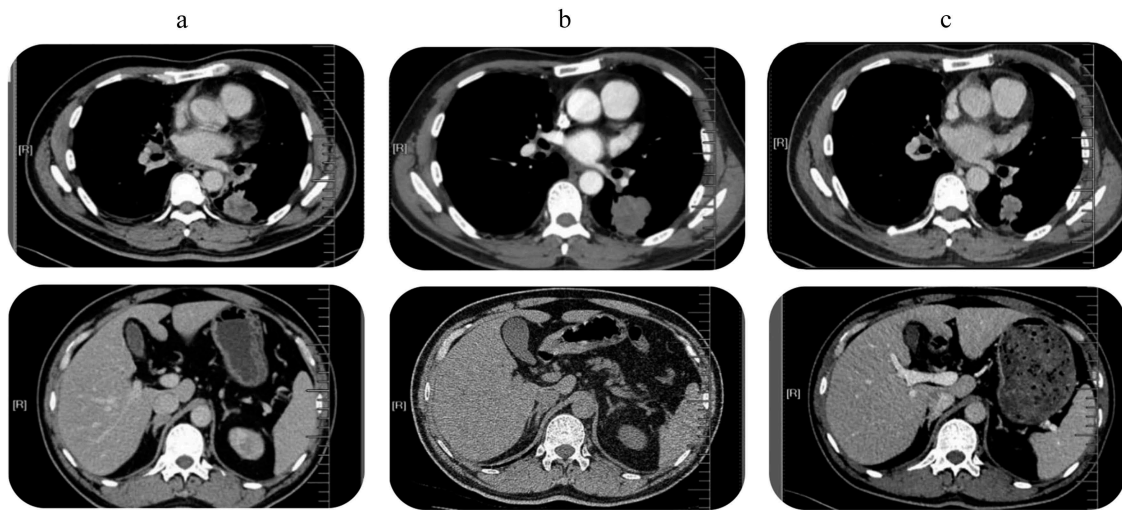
Tumor lesions detected by PET-CT. (a). Before the start of TKI treatment: central lung tumor in the left lower lobe mass infiltrating the hilum and mediastinum and bilateral adrenal metastases; (b). Progression after 6 months of erlotinib: enlarged pleural mass that showed transformation to SCLC. (c) Partial response after four cycles of EP chemotherapy and erlotinib continuation: Dramatic shrinkage of the primary lung tumor.
